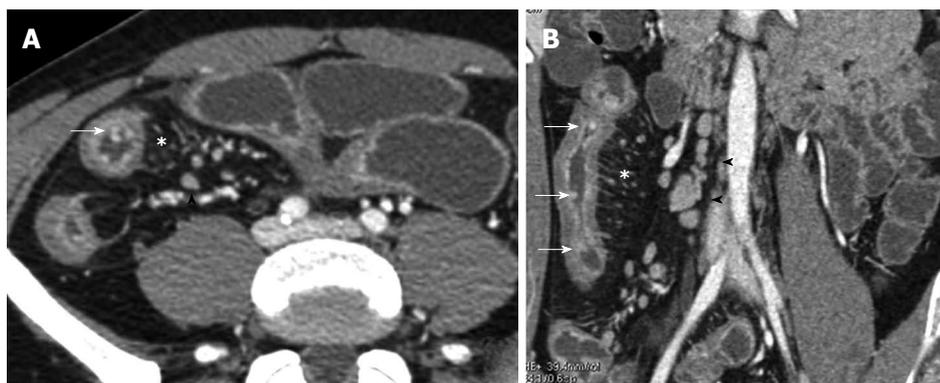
Transverse (A) and coronal (B) computed tomography show bowel wall thickening and mucosal hyper-enhancement with pseudo polyps (white arrows) as well as mesenteric lymph nodes, that are irregular in size and shape (black arrowhead) and increased mesenteric vascularity (asterisk). These features may be detected in case of acute exacerbation on a background of longstanding disease.
